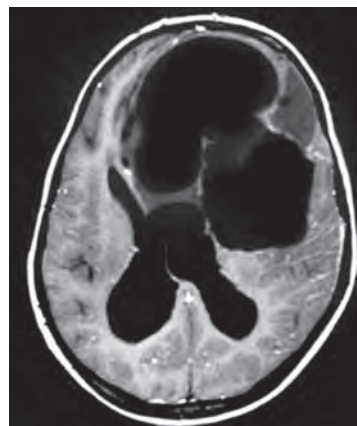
MRI of the brain showing hydatid cyst with hydrocephalus
